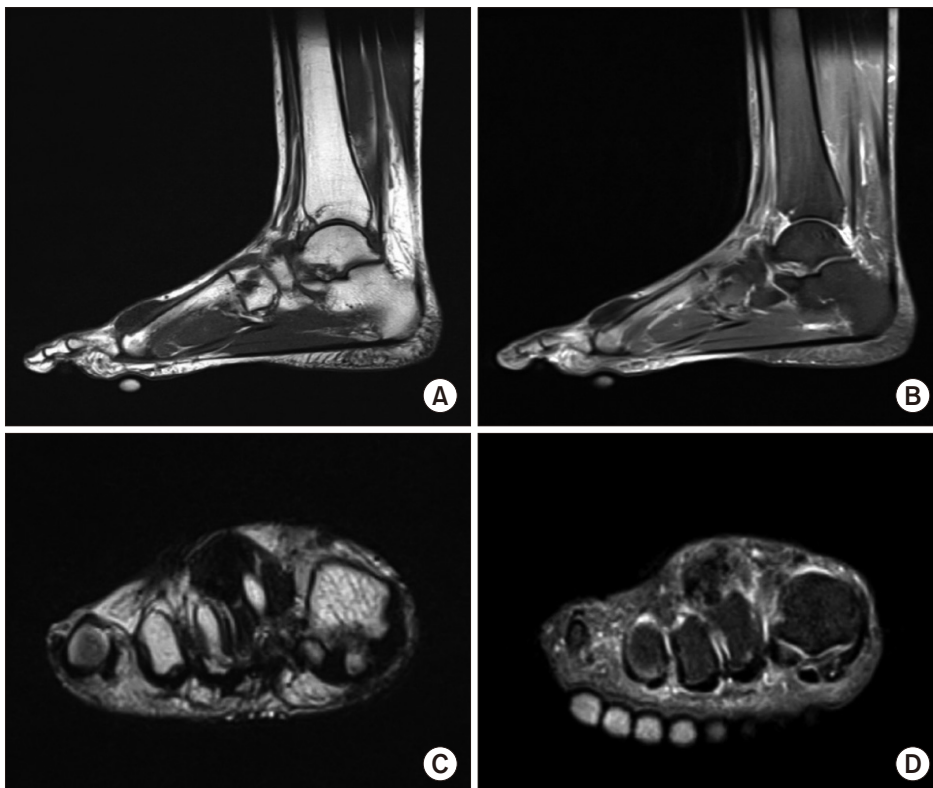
Magnetic resonance imaging (MRI) findings. (A) The tumor was well-defined heterogeneous low signal intensity on sagittal T1-weighted MRI image, located in the dorsal side of 2nd metatarsophalangeal (MTP) joint adjacent to the extensor digitorum longus (EDL) and extensor digitorum brevis (EDB). (B) The tumor shows same heterogeneous low signal intensity on sagittal T2-weighted MRI image. (C) Coronal T1-weighted MRI image revealing a mass firmly adherent to the dorsal side of 2nd MTP joint capsule and conjoined tendon of EDL and EDB. (D) The tumor on coronal T2-weighted MRI image shows same heterogeneous low signal intensity.
